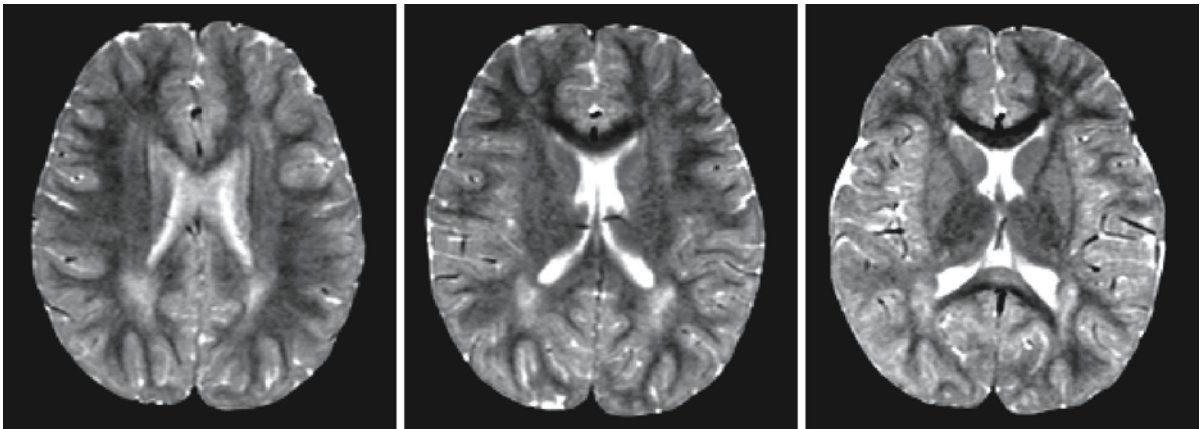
MRI in a 5 1/2-year-old boy, who was diagnosed with metachromatic leukodystrophy (MLD) and extensive white matter abnormalities 3 years later. The areas of higher signal in the deep parietal white matter are often seen as a nonspecific finding, but the lesion in the splenium of the corpus callosum
